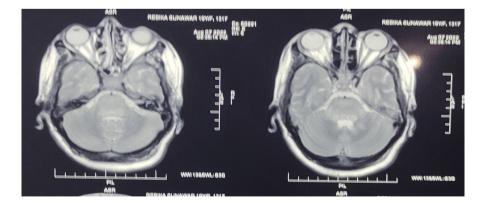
Hyperintense T2/FLAIR coronal images on pons and in left middle cerebellar peduncle, insular lobe, and adjacent thalamus.
